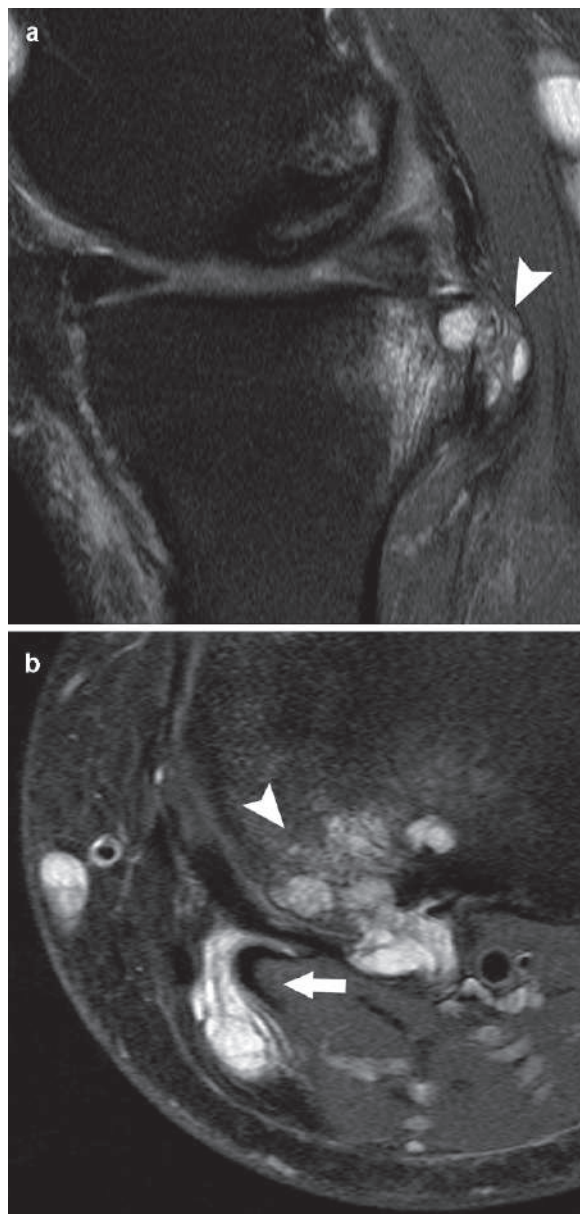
Sagittal (a) and axial (b) PD knee MRI shows juxta-articular intra-osseous ganglion cysts formation in the posterior part of the tibia with bone marrow edema due to knee OA (*arrowheads*). A small Baker cyst can be seen as a secondary finding (*arrow*)
